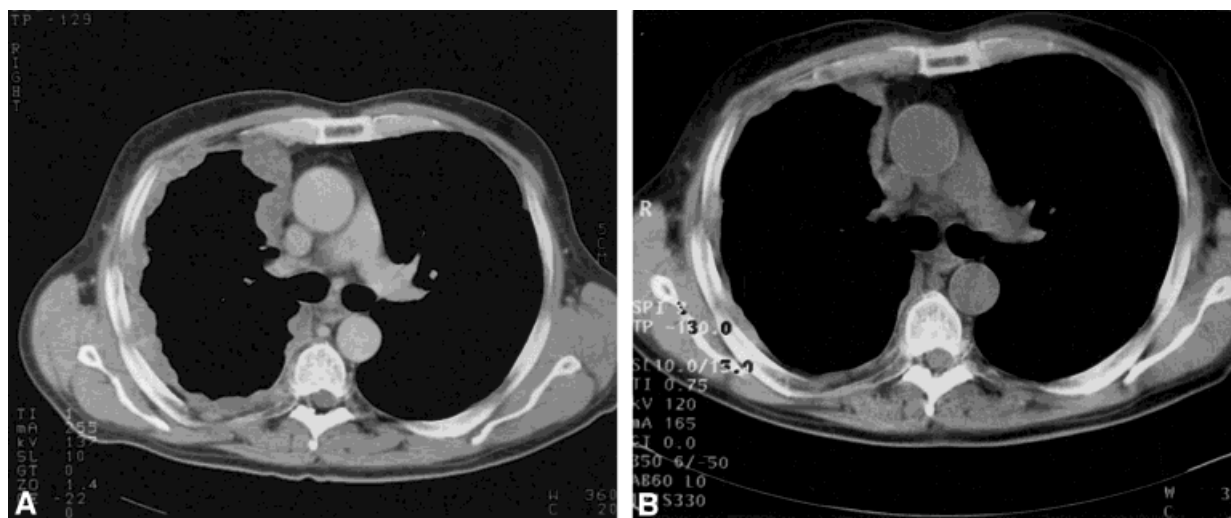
Computed tomography scan of the thorax in a patient with malignant pleural mesothelioma obtained (A) before and (B) after two cycles of gemcitabine shows a partial remission of the target lesions within the thorax. These findings were confirmed 4 weeks later.
